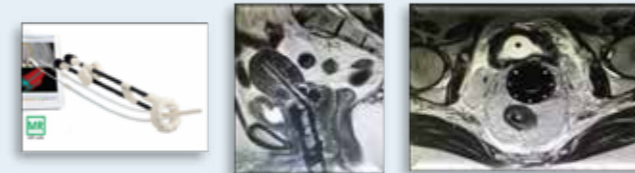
Interstitial Ring CT/MR Applicator Set (left), T₂-weighted image with the applicator in-situ (centre / right: sagittal / axial plane)
